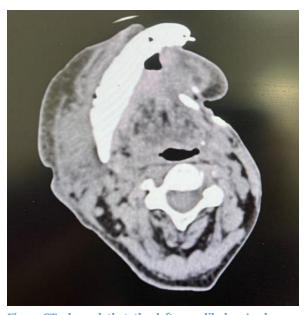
CT showed that the left mandibular Angle was largely missin
